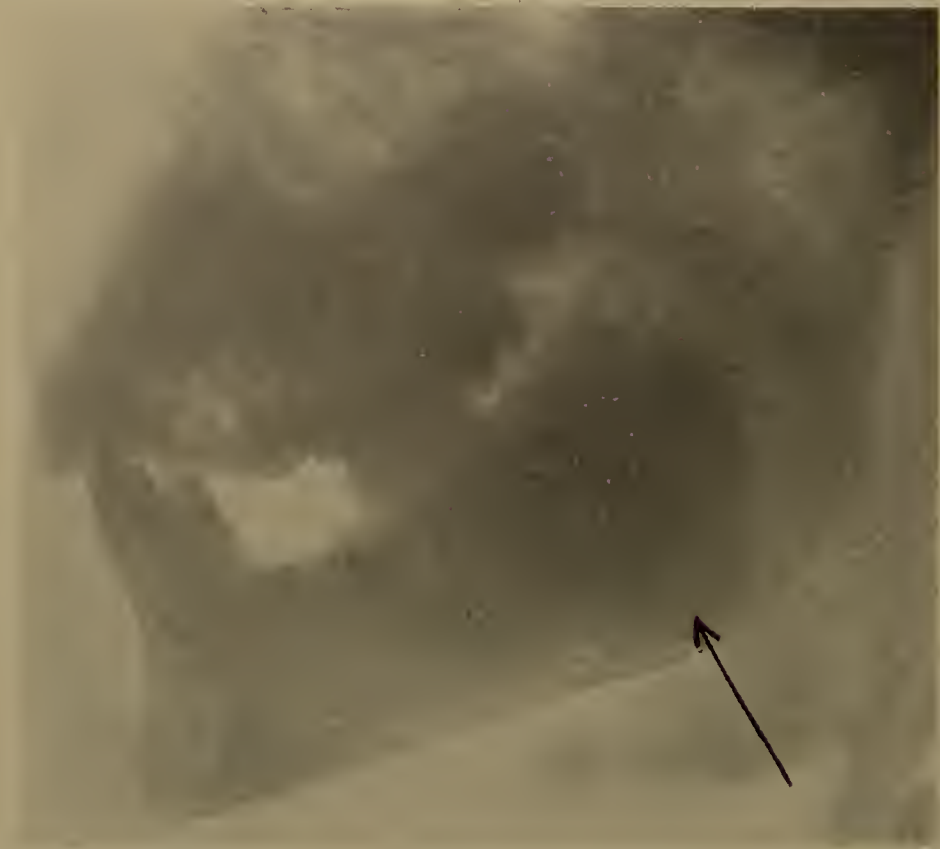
An *x*-ray of a hard odontoma. Note the odontoma at the point of the arrow. (See Figs. 233, 234.) (X-ray by Dodd.)
